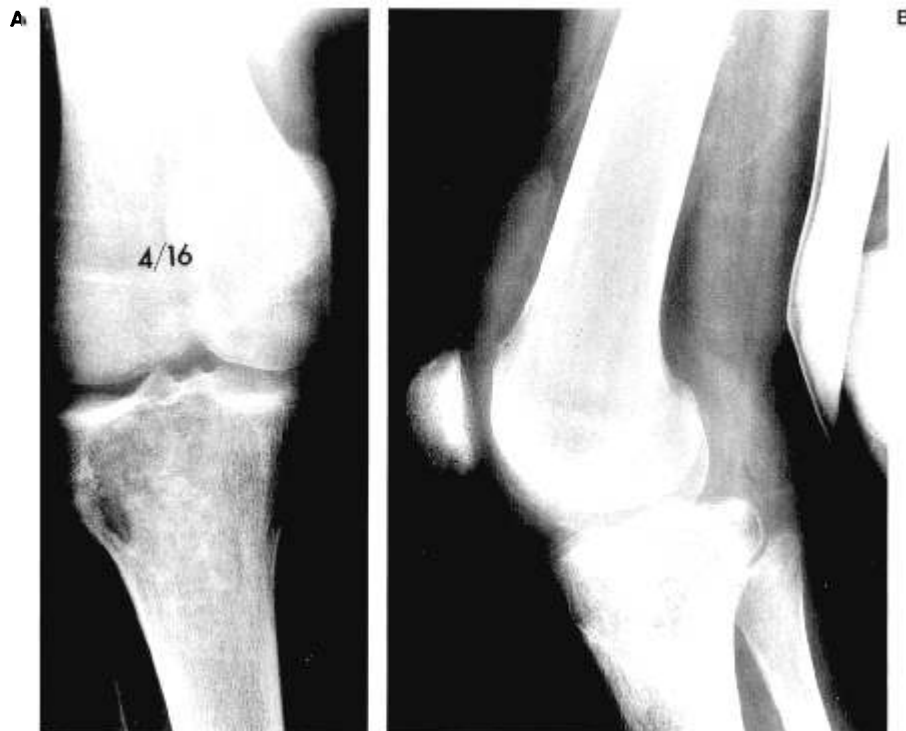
Anteroposterior (A) and lateral (B) radiographs of knee in a 23-year-old man 4 months postharvesting of proximal tibial metaphyseal bone graft. Postoperative findings are consistent with giant cell tumor. A biopsy was recommended to the patient.
